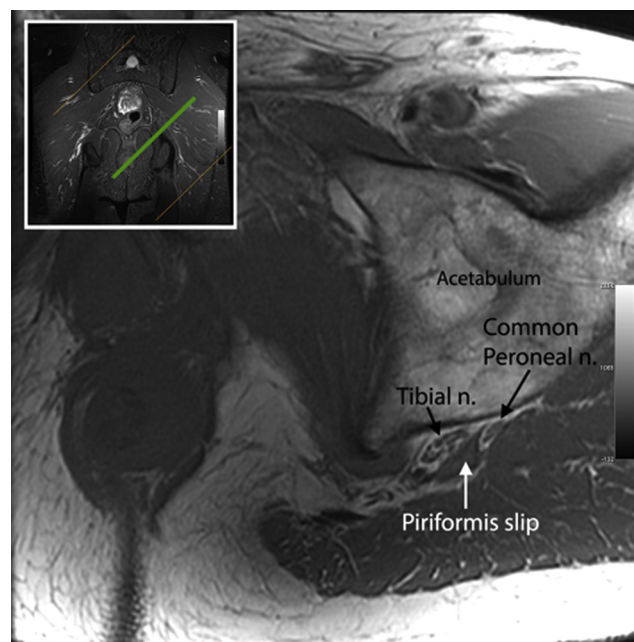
A coronal T2-weighted magnetic resonance image (MRI; inset) shows a green line representing the scan plane for the compound oblique T1-weighted MRI through the level just below the sciatic notch. Note the piriformis slip dividing the tibial and common peroneal components. n = nerve.
